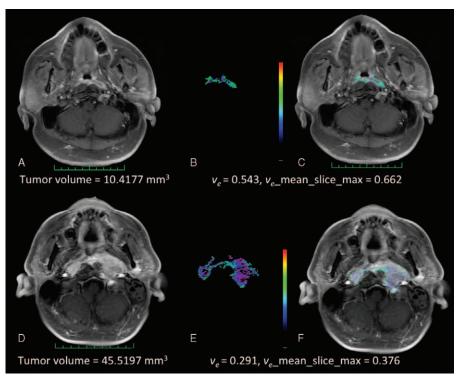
(A-F) Representative pretreatment MR images of 2 NPC patients. The upper row depicts a patient (case # 16, panels A-C) with an AJCC T1N2 malignancy and DM. The lower row depicts a patient (case # 24, panels D–F) with an AJCC T4N3a and no DM. The measurements of tumor volume (panels A, D),  $v_e$  values (panels B, E), and overlying postcontrast T1WI (C, F) images are shown for comparison purposes. AJCC = American Joint Committee on Cancer, DM = distant metastases, MR = magnetic resonance, NPC = nasopharyngeal carcinoma.
